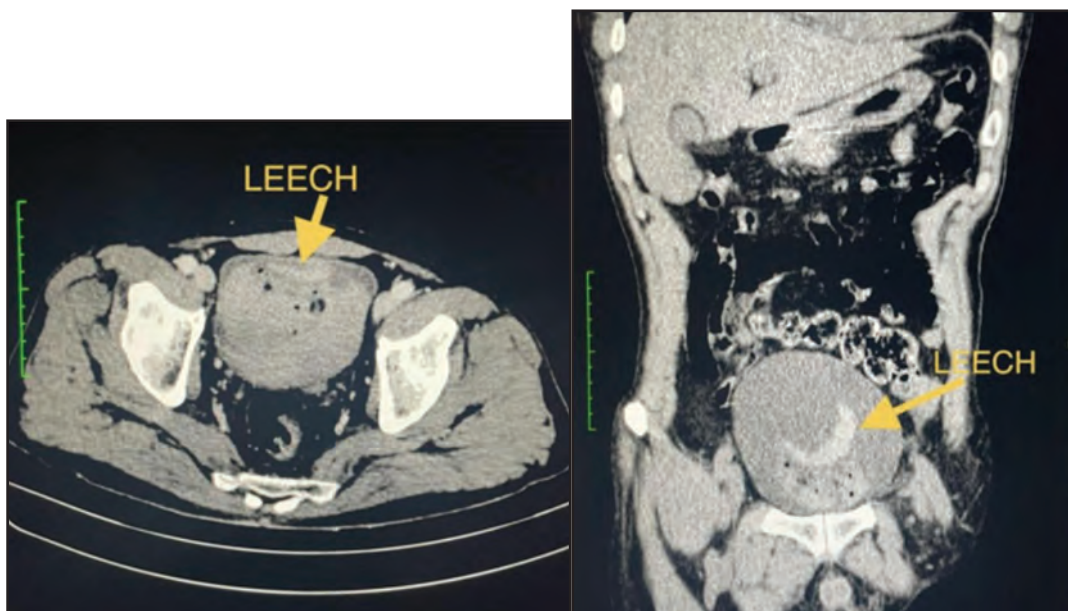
CT images. Axial and coronal images from contrasted CT abdomen show tubular structures within the urinary bladder with blood clots suggestive of leech
